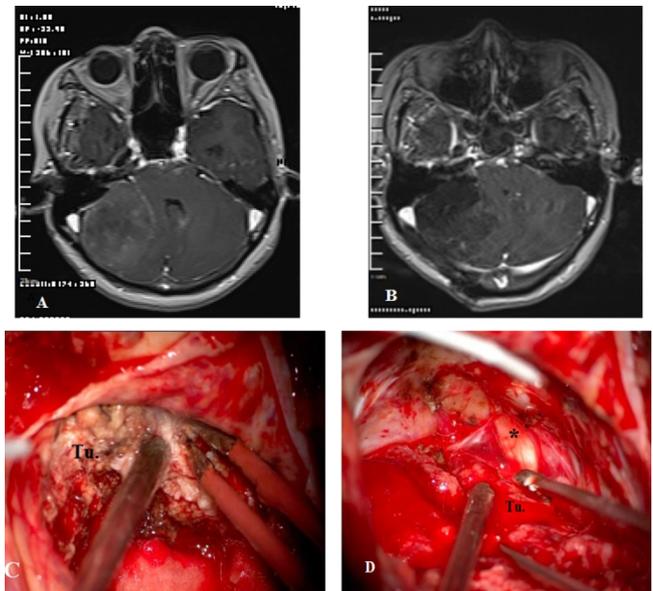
A preoperative axial T1-weighted Gd-enhanced MRI (A) demonstrate a CPA meningioma posterior to the IAC. A postoperative axial T1-weighted Gd-enhanced MRI (B) revealing gross-total resection of the tumor via the retrosigmoid approach. Intra-operative images demonstrate the process of internal decompression (C) and dissecting the anterior capsule of the tumor from the facial nerve (D). The VII-VIII complex appears at the end of the tumor removal. Tu. Tumor, * VII-VIII complex.
